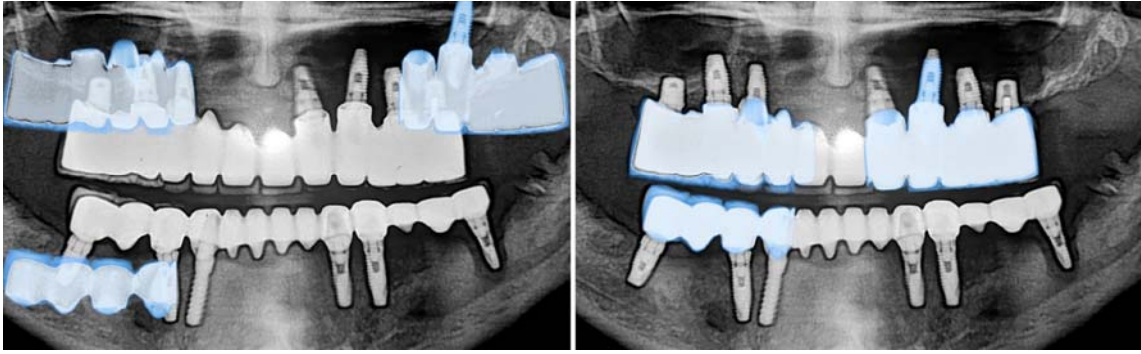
A. Transparent post-mortem radiographic images (blue) superimposed on the ante-mortem panoramic radiograph. B. Minor corrections for size and angulation resulted in a near perfect superimposition of the ante- and post-mortem radiographs.
